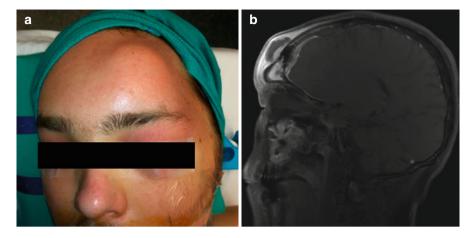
(a) Patient with left forehead Pott's Puffy tumor. (b) MRI brain T 1 post contrast of the same patient showing a subgaleal abscess, left frontal sinus mucosal thickening and inflammation and left frontal lobe epidural enhancement
